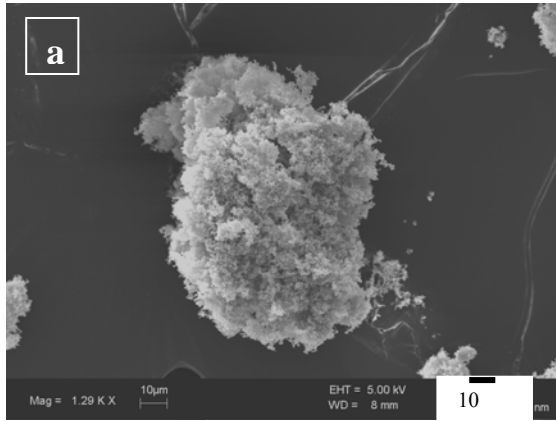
Effect of ultrasonic energy and temperature on deagglomeration and mixing of dipyrindamole and PVP particles at 35% ultrasound amplitude, 78 bar CO₂ pressure, ultrasound energy input 68 MJ/m³, drug/PVP weight ratio 1/1, and 10 °C: (a) presence of typical agglomerate of drug particles held together due to fusion (melting) of PVP, and (b) higher magnification of (a) showing presence of individual drug particles held together by fused (melted) PVP.
